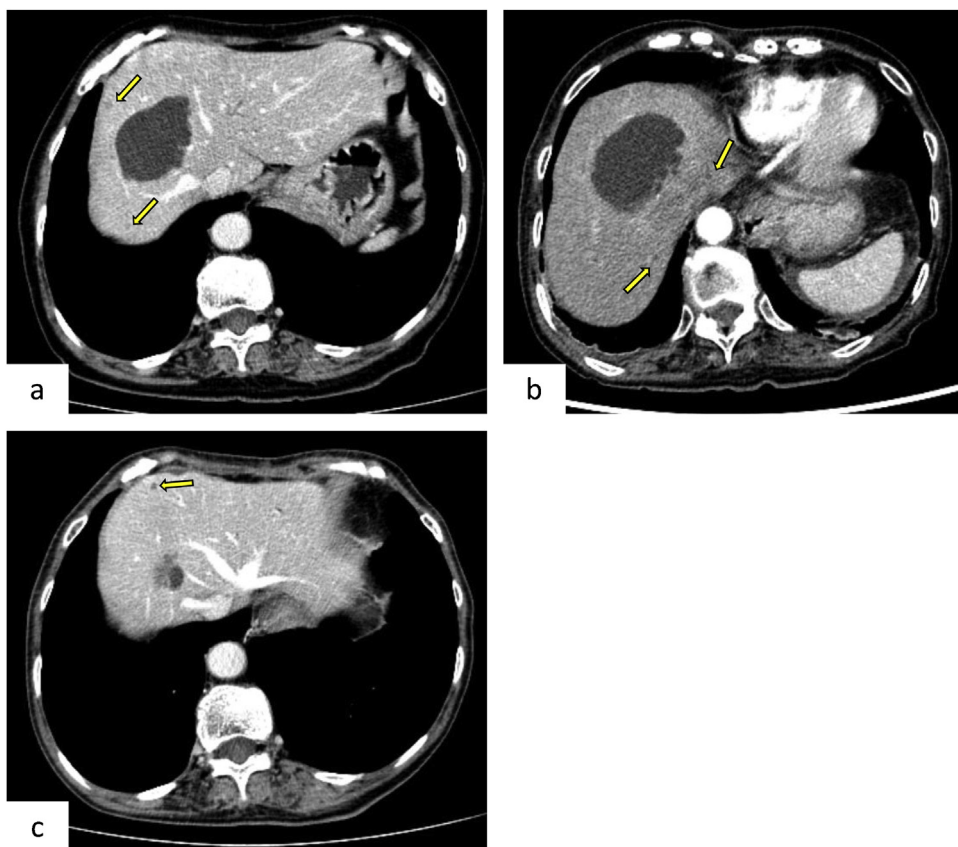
Contrast-enhanced abdominal computed tomography (CT).
